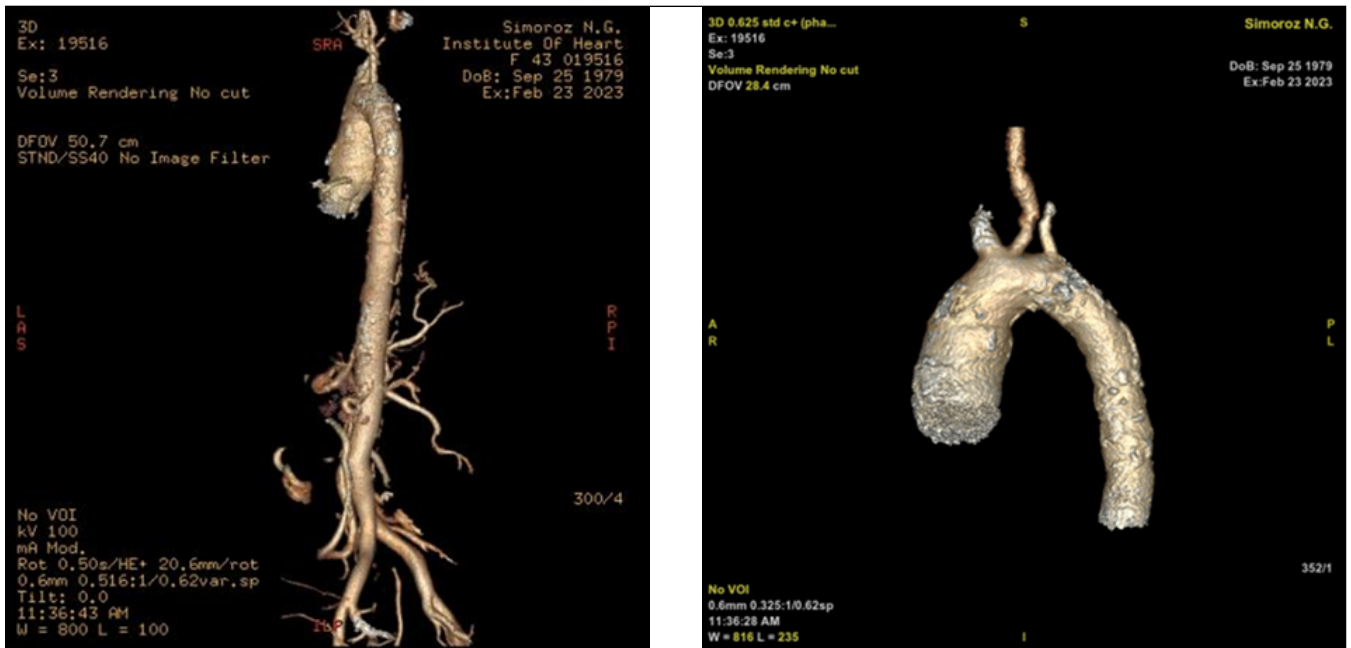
MSCT – aortography. CT features of non-specific aortoarteritis (Takayasu) with signs of occlusion of the right CCA and both subclavian arteries, dilation of the ascending aorta, the superior mesenteric artery not visualized, occlusion cannot be ruled out.
